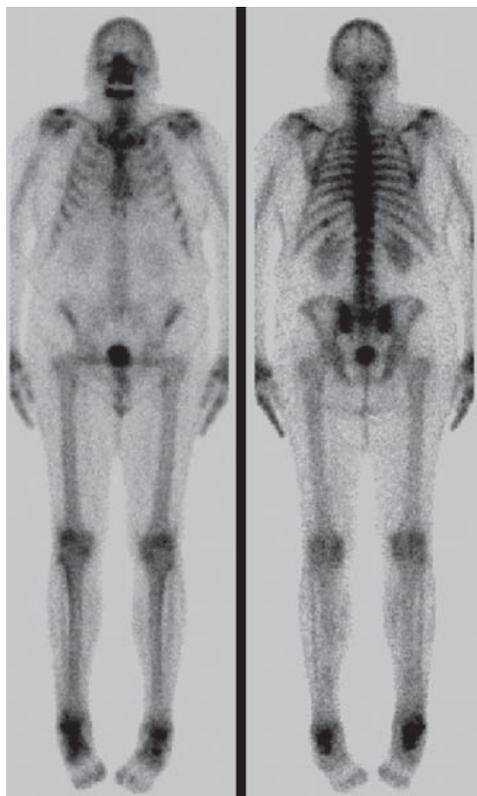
Bone scintigraphy. Case nr. 4.
